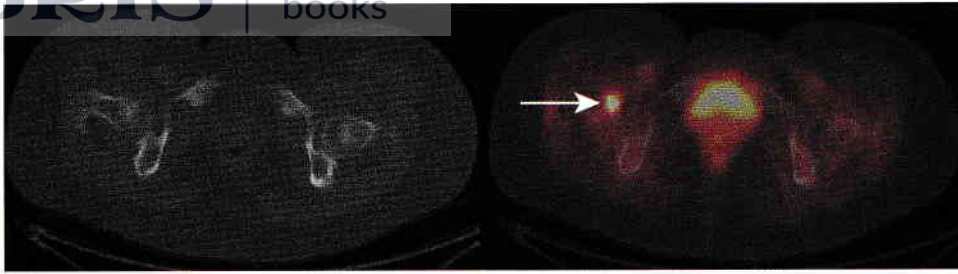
Axial FDG PET through the pelvis in a patient with breast cancer. There is an FDG focus in the right pelvis (arrow). The midline FDG avidity is urine in the bladder.
